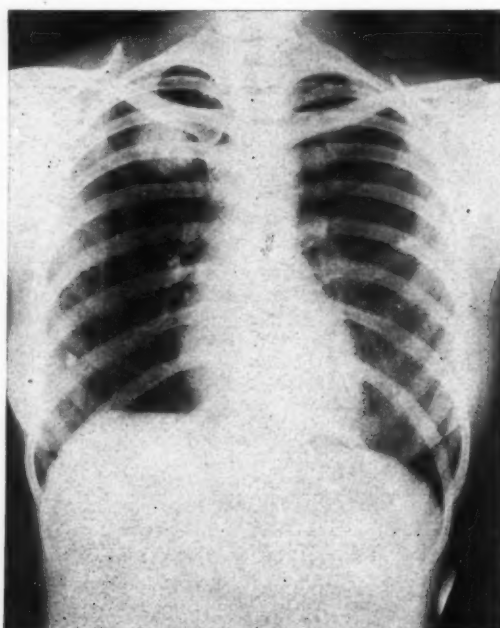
Roentgenogram made about 11 months before figure 1 showing lesion to have been solitary and circumscribed.
